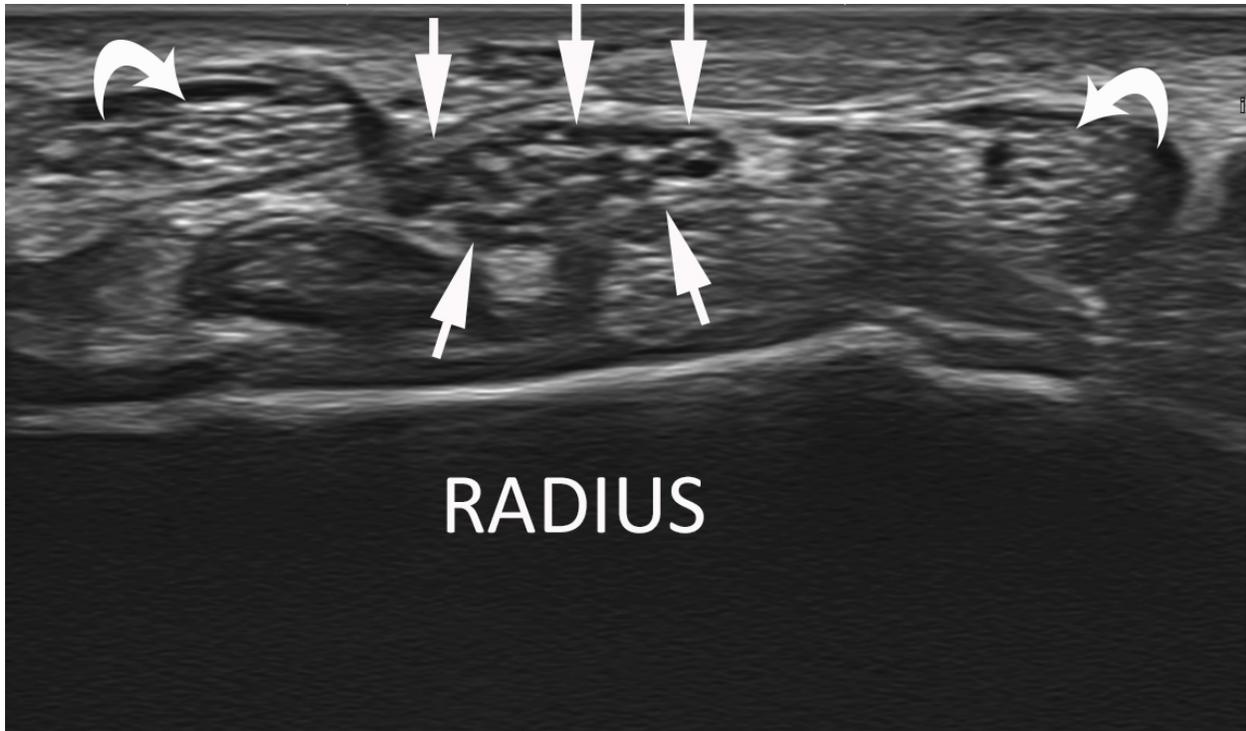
Normal median nerve. Ultrasound image obtained using a 24-MHz transducer shows a transverse section of a normal median nerve over the distal radius (straight arrows) with hypoechoic circles representing nerve fascicles on a hyperechoic background representing epineurium between fascicles. Contrast this with the finer fascicular appearance of two adjacent flexor tendons (curved arrows).
